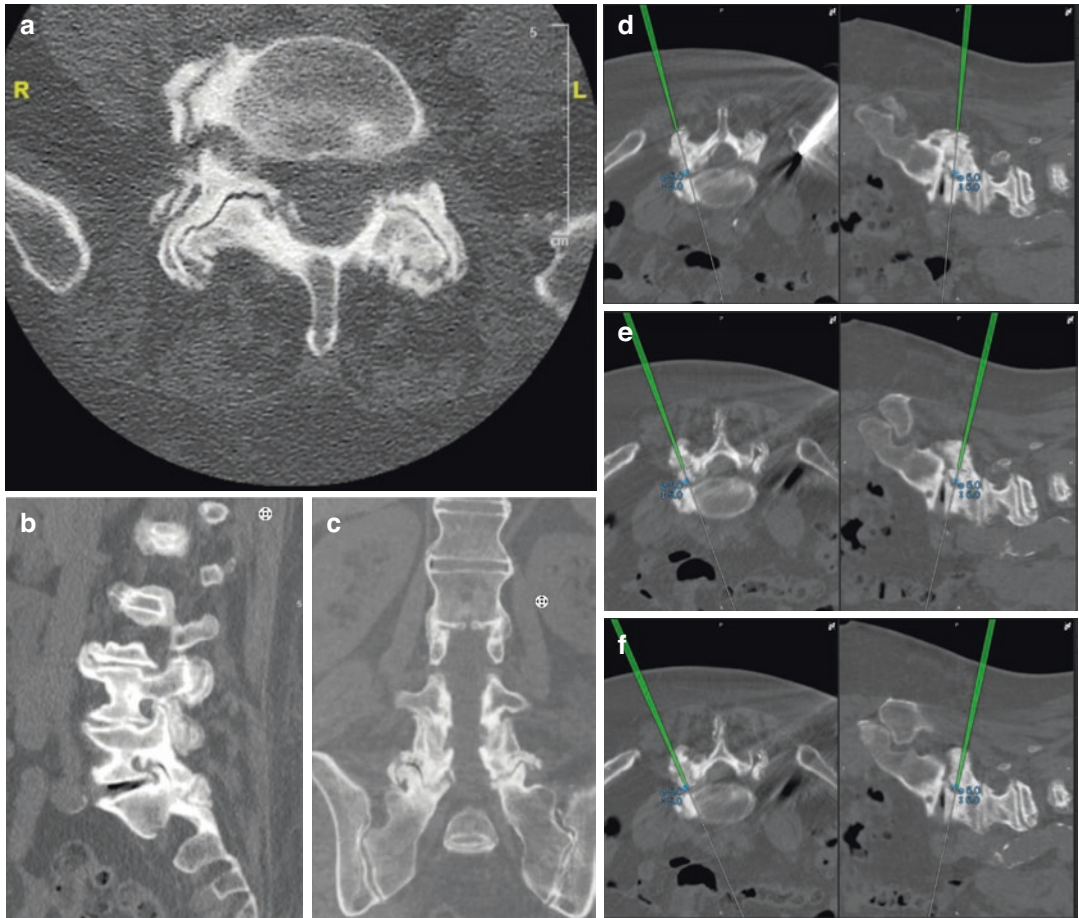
Advanced facet arthropathy with hypertrophy, hook osteophytes, and a disc ridge complex causing severe right-sided L5-S1 foraminal stenosis. (a) Axial CT images; (b) Sagittal CT images; (c) Coronal CT images; (d, e, f) Intraoperative navigation aids removal of the lateral aspect of the facet joint; (f)
